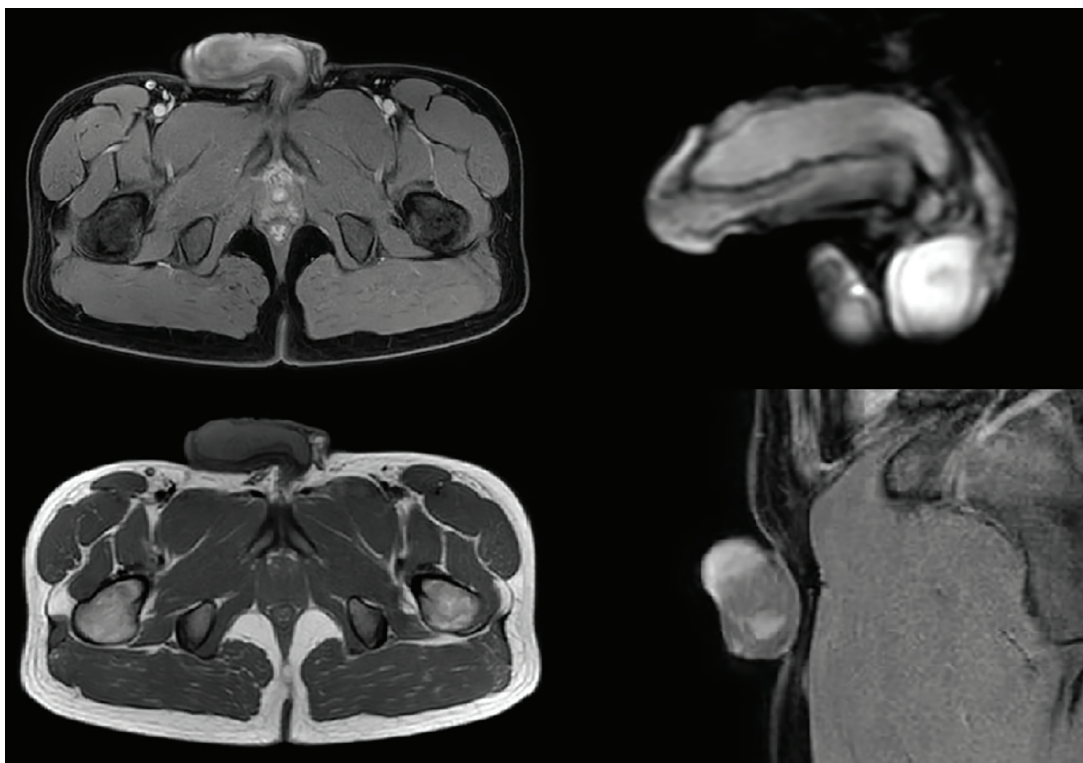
Penile magnetic resonance imaging of a lesion starting from the distal corpus cavernosum of the penis and extending to the proximal corpus cavernosum.
